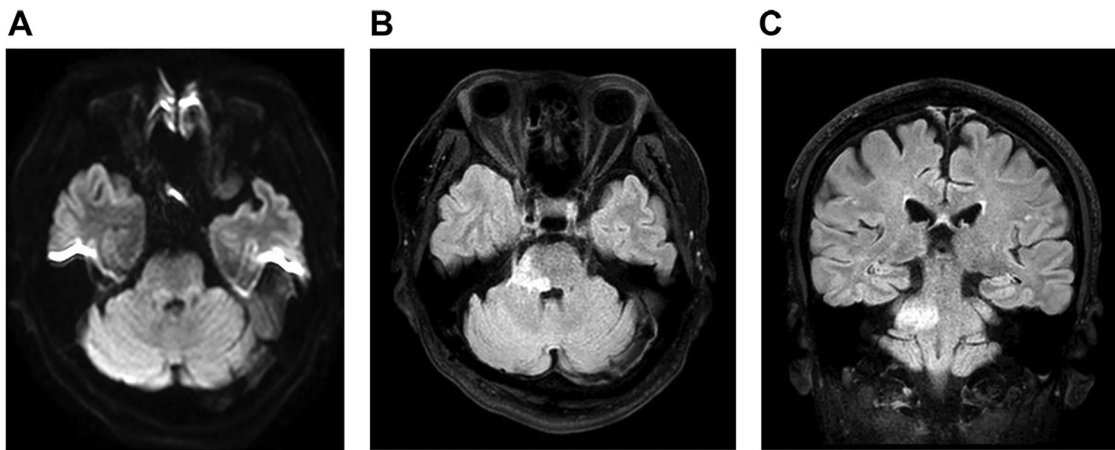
MRI imaging after 1st TVE A: Brain MRI after the first TVE showing isointensity signal at diffusion-weighted imaging (A) B and C: High intensity signal at fluid-attenuated inversion recovery indicated vasogenic edema due to venous congestion. MRI, magnetic resonance image; TVE, transvenous embolization.
